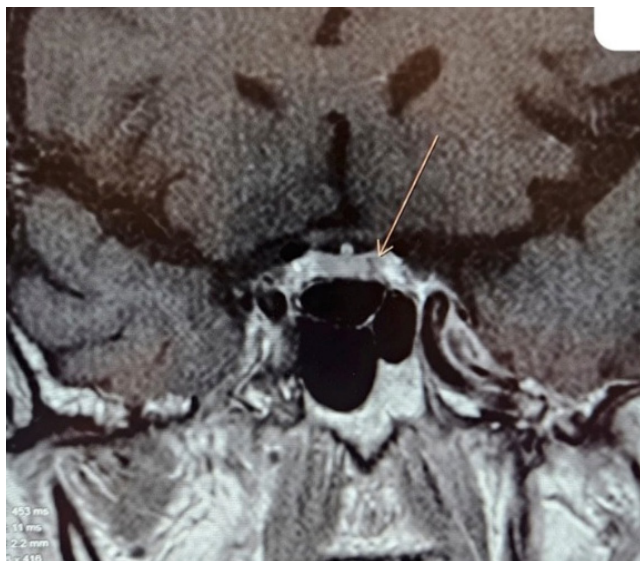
Coronal contrast-enhanced T1-weighted magnetic resonance imaging of the brain showing a non-discrete hypointense area in the pituitary gland suspicious of a microadenoma (arrow).
